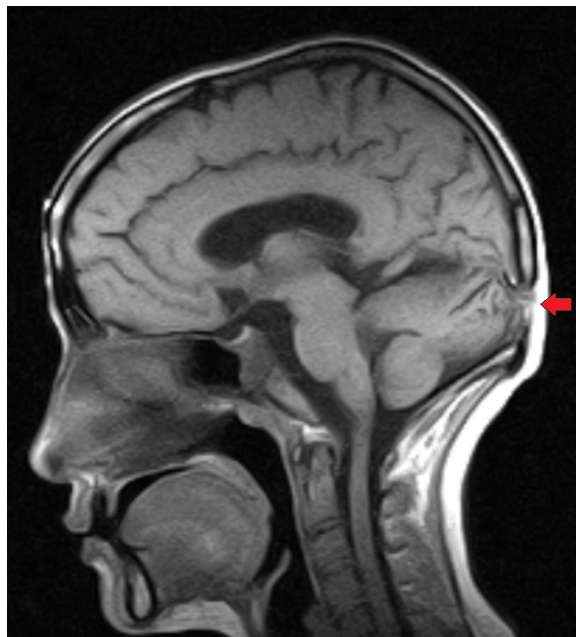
T1 weighted sagittal image of magnetic resonance imaging of brain showing atretic meningocele in occipital region (red arrow)
